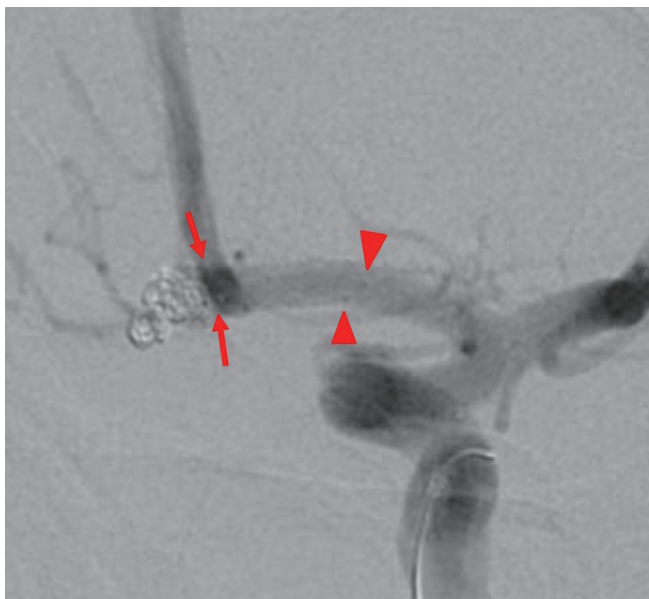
Preoperative images showing. A: X-ray image, B: Angiography of the working angle
